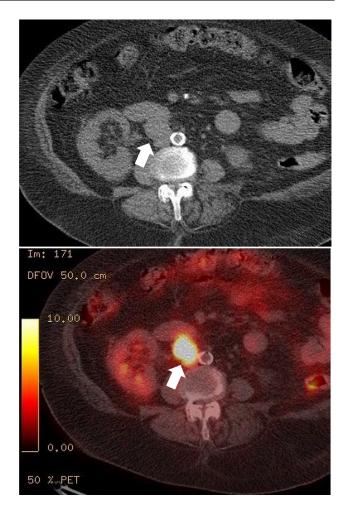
First PET-Scan showing enlarged FDG avid right-sided nodule anterior to the IVC measuring 26 mm in short axis with an SUV max of 17.6 (arrows).
